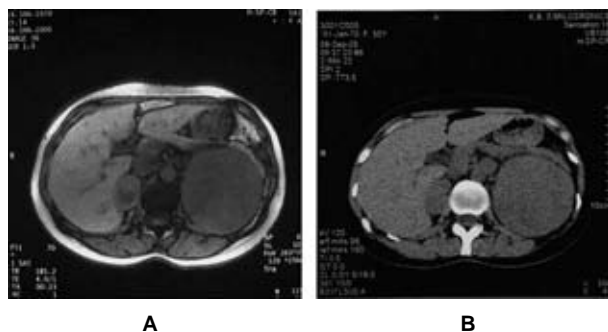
(A) Abdominal MR imaging: giant bilateral adrenal pheochromocytoma (left adrenal tumor: 11×9 cm; right adrenal tumor: 4×3 cm in size). (B) Abdominal MSCT: bilateral pheochromocytoma with a partially necrotic zones during octreotide treatment.
